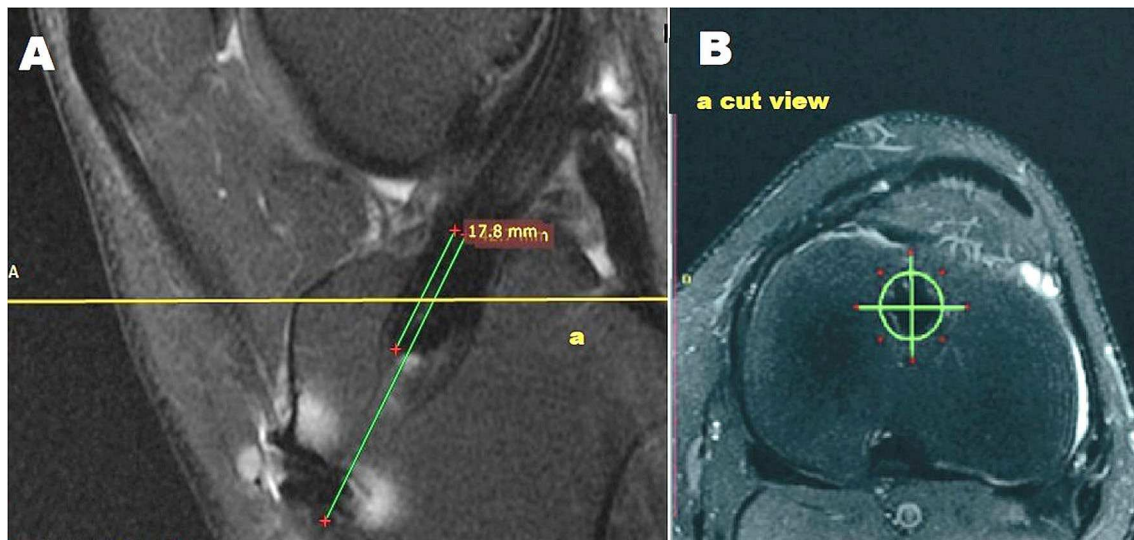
Method of analysis of bone-graft contact and tibial graft volume. A Sagittal T2 MRI section through the tibial tunnel with line a showing the cut level of the axial T2 section (B). The tibial tunnel was divided in four parts to calculate tibial graft volume and bone-graft contact [1, 8]
